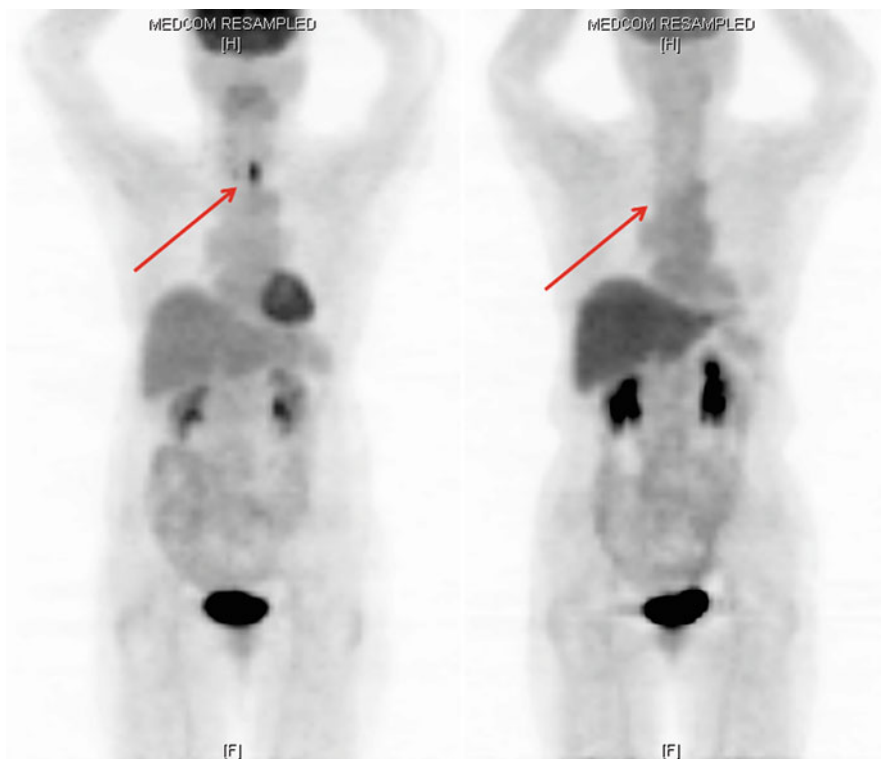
On the left-hand side is an F18-FDG PET scan showing abnormal FDG uptake, consistent with malignancy, in the esophagus at the level of the thoracic inlet (*red arrow*). On the right-hand side is a negative F18-FDG PET scan showing interval resolution of disease in the proximal esophagus at the thoracic inlet after induction chemotherapy (*red arrow*). No new disease identified
